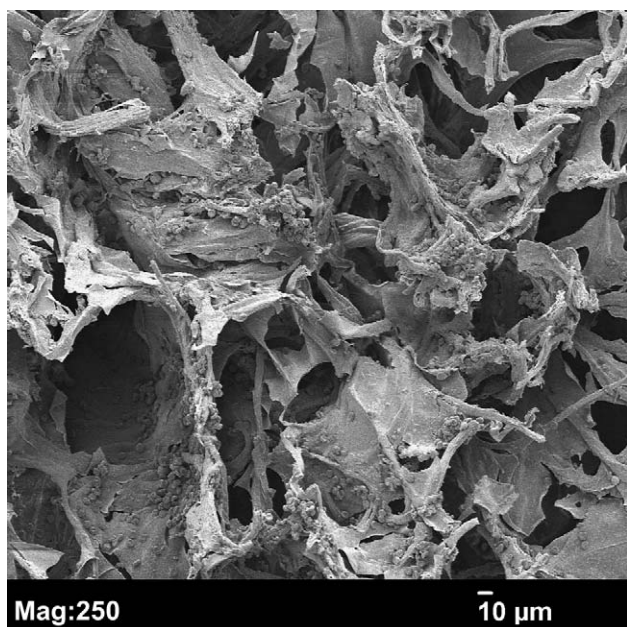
The collagen fibrous matrix is uniformly coated with hydroxyapatite through a patented mineralization process. The final product is approximately 30% hydroxyapatite by weight and completely radiolucent on plain radiographs. It has an interconnected pore size of 4–200 microns, similar to human cancellous bone.
